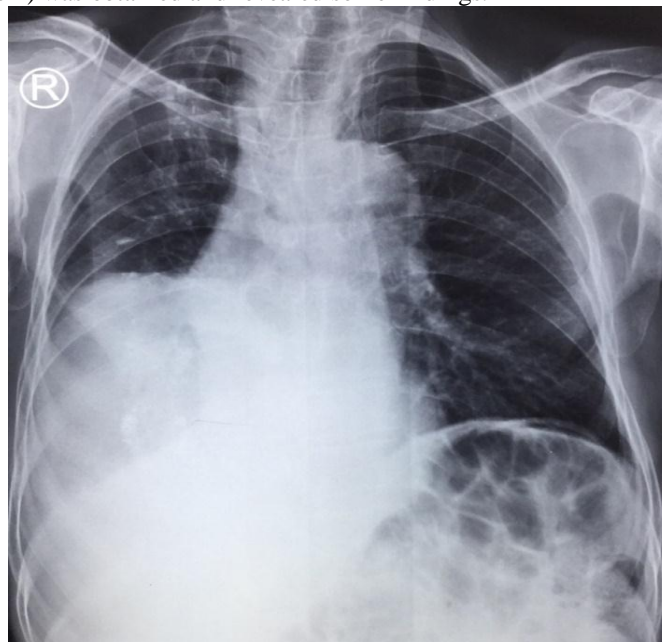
Frontal chest radiograph showing a right lower zone opacity overlapping the mediastinum which appears broad based to the chest wall and showing high density calcific foci noted within. The lateral border of the opacity was indistinct.
